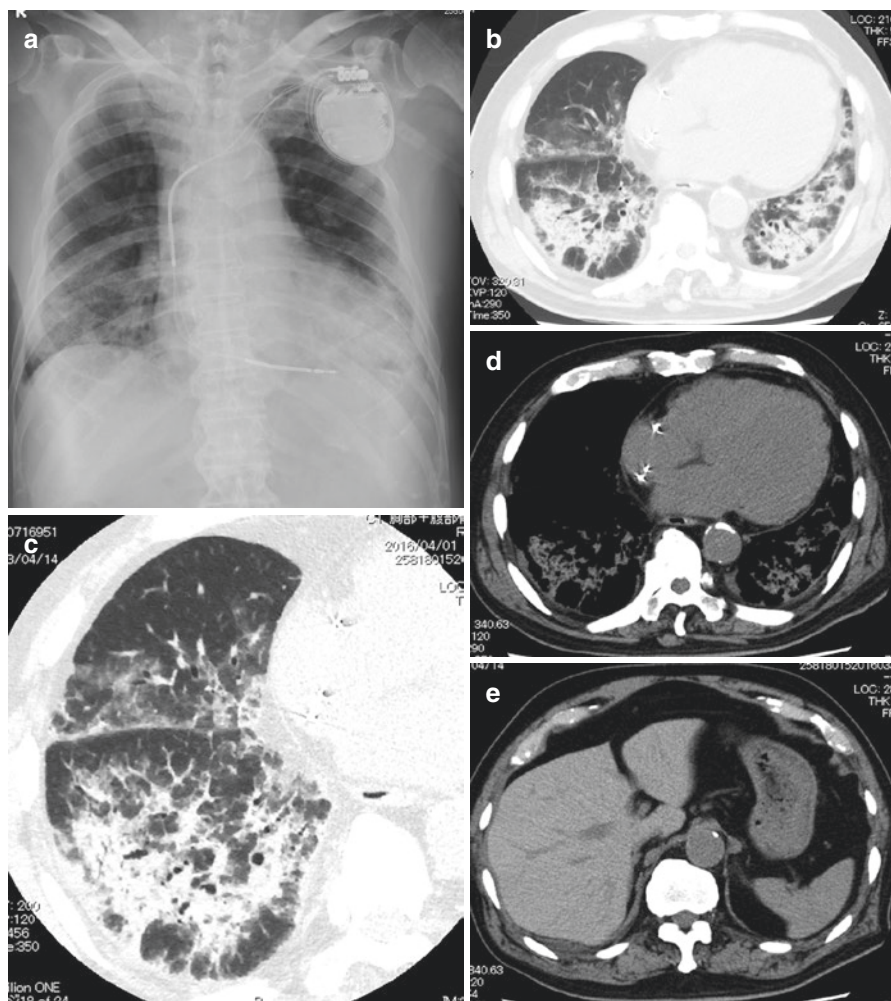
Hypersensitivity pneumonia-like lung injury (methotrexate and infliximab for rheumatoid arthritis). (a) Chest X-ray shows diffuse ground glass opacity (GGO) obscuring pulmonary vascular markings in bilateral lungs. (b) High-resolution computed tomography (HRCT) shows widespread patchy panlobular GGO. (c) HRCT shows widespread patchy panlobular GGO
